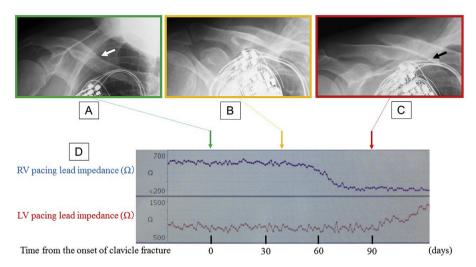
Panel A: An X-ray taken at the time of the clavicle fracture shows a fracture line (indicated by the white arrow), but no displacement of the clavicle. Panel B: An X-ray taken 40 days after the clavicle fracture shows apparent dislocation of the distal clavicle. Panel C: An X-ray taken 90 days after the clavicle fracture shows further displacement of the distal clavicle and flexion of the right ventricular (RV) lead (indicated by the black arrow). Panel D: Time course of RV and left ventricular (LV) lead impedance. Changes in the RV lead and LV lead impedance started after the distal clavicle had been dislocated.
